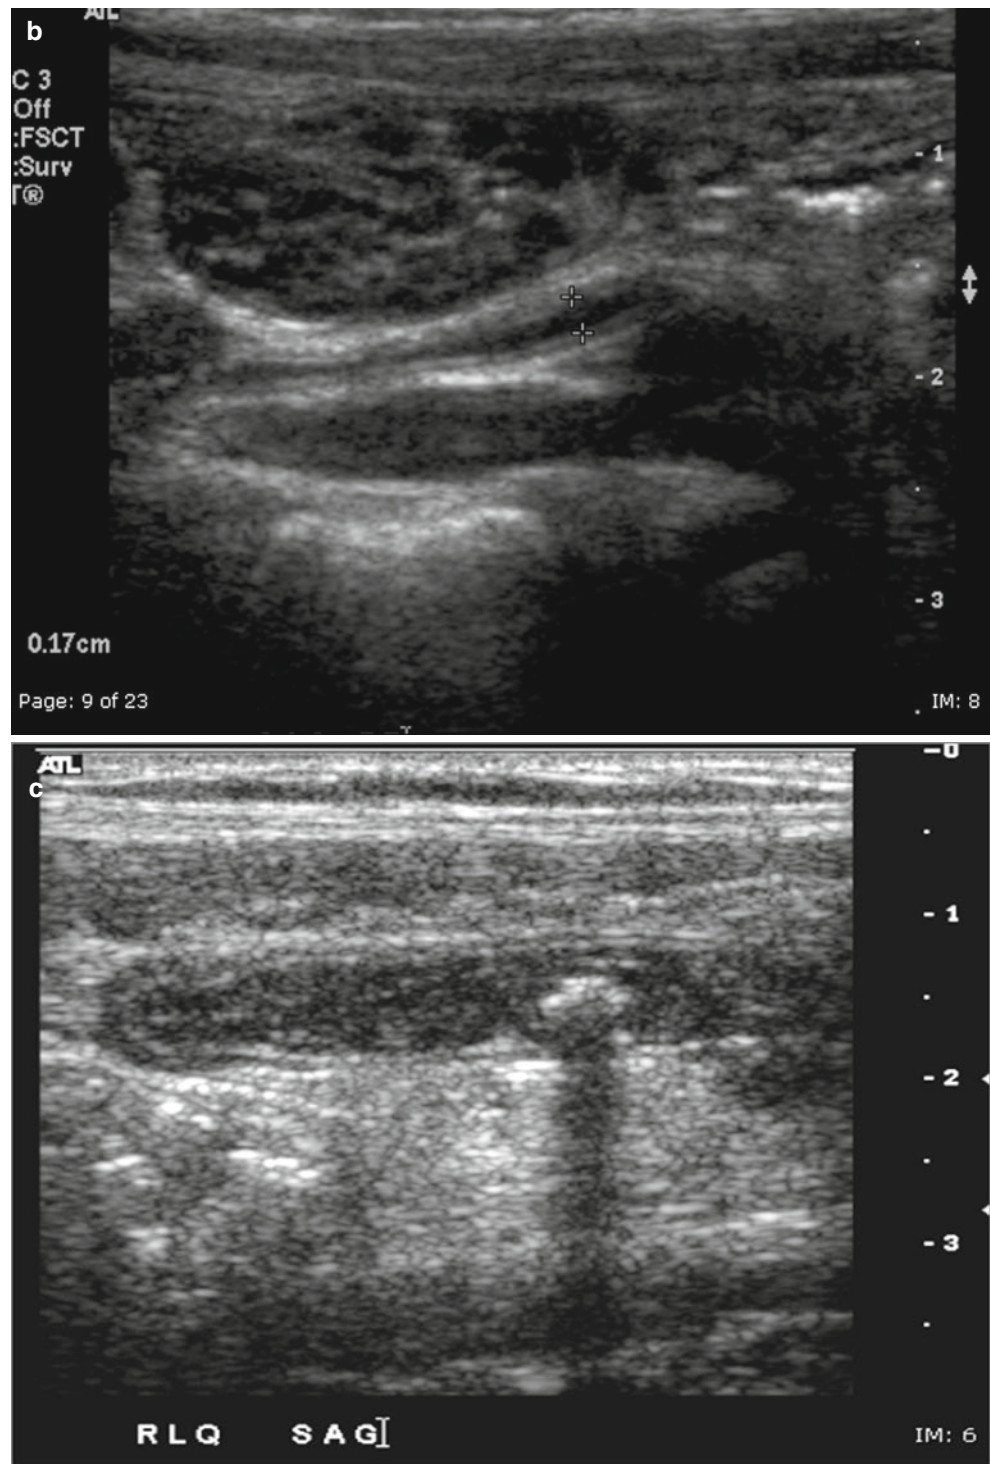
(a) Ultrasound demonstrating a noncompressible tubular structure on ultrasound, with a transverse diameter of >6 mm, consistent with acute appendicitis. (b) Ultrasound demonstrating a longitudinal view of a noncompressible tubular structure with thickened walls consistent with acute appendicitis. (c) Endoluminal fecalith on ultrasound
